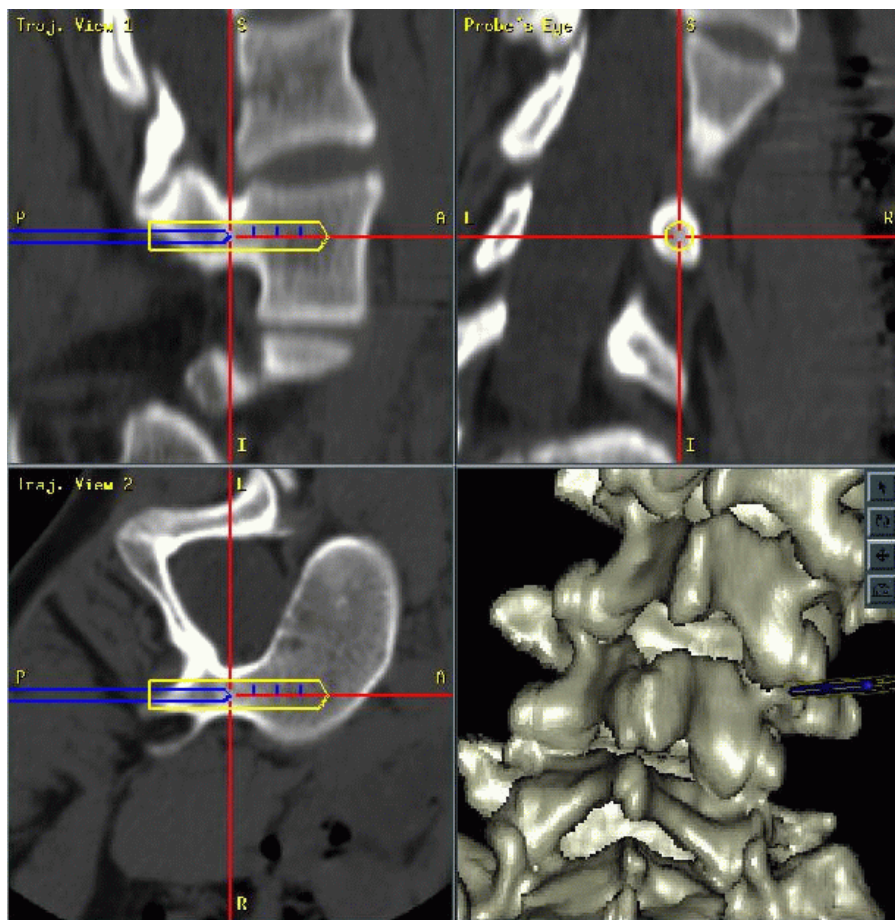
The position and orientation of the pedicle screws can be planned preoperatively using a CT scan and a planning computer
